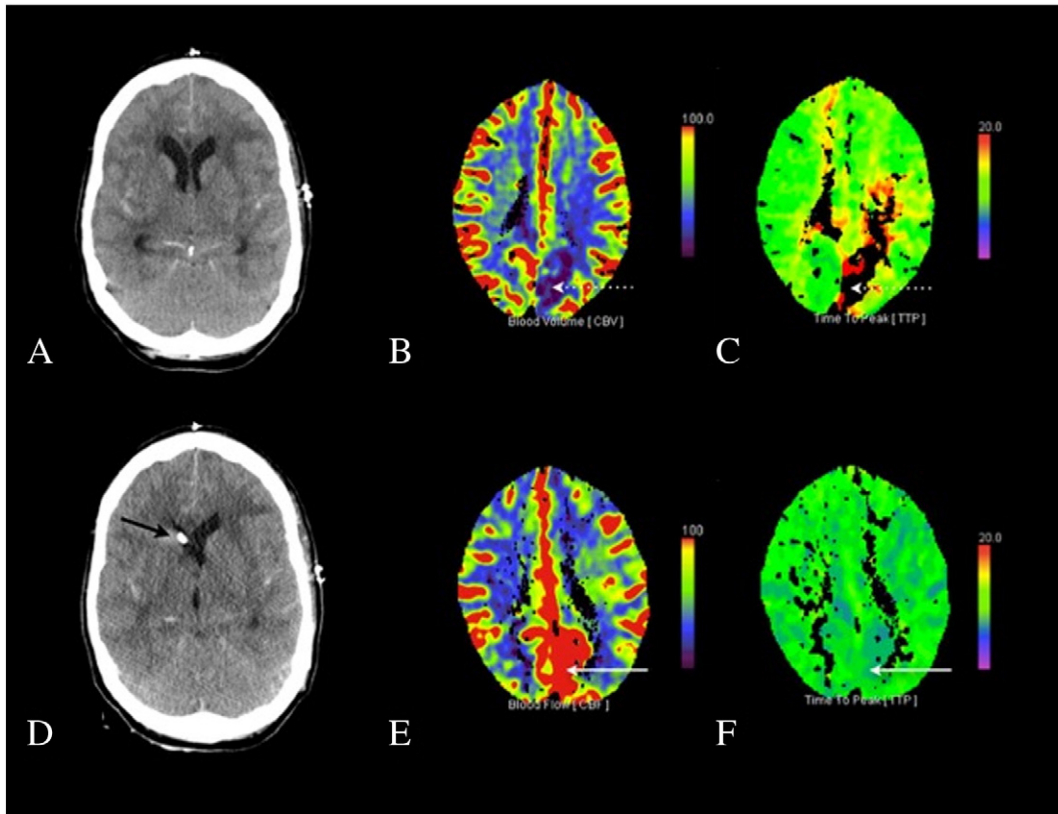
Initial CT scan showed generalized edema and mild hydrocephalus (A), with hypoperfusion on cerebral blood flow (CBF) and time-to-peak (TTP) maps (B, C) within the left PCA territory (white dotted arrow); after EVD placement and drainage (D, black arrow), perfusion was restored within the respective territory (F, G; white arrows), indicating sufficient release of the left PCA along the tentorial edge.
